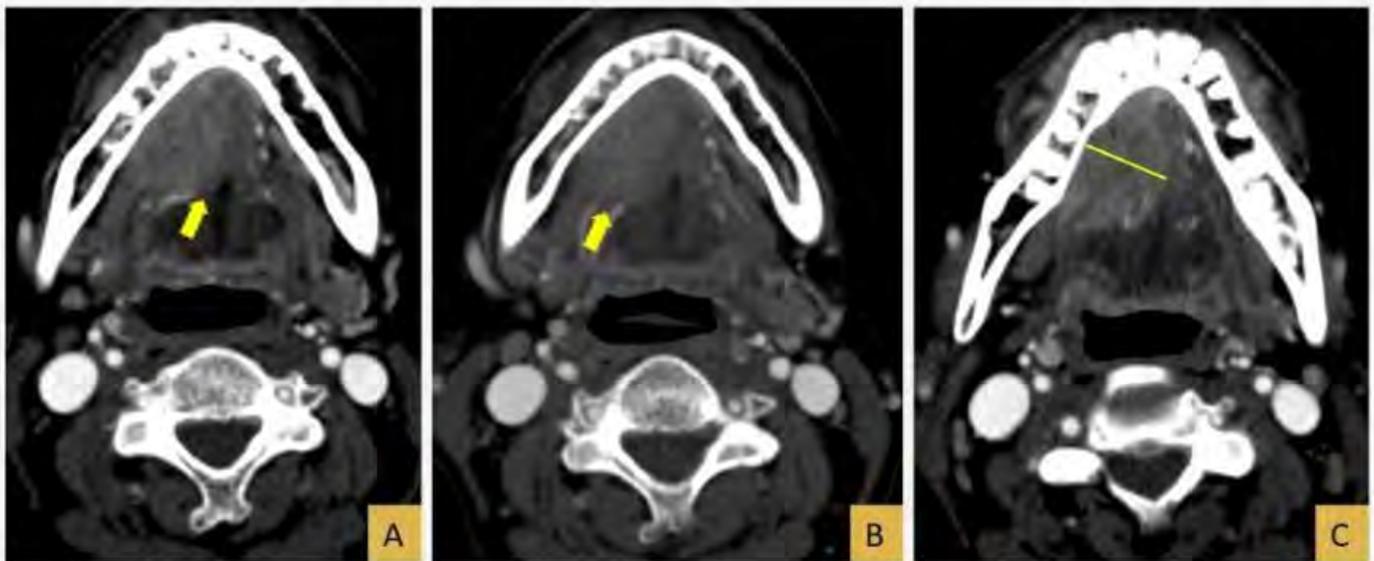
CT neck with contrast: Squamous cell carcinoma of the right floor of mouth. A) Arrow points to mass-like enhancement involving the right genioglossus muscle. B) Arrow points to mass-like enhancement involving the right hyoglossus muscle. C) Depth of invasion is approximated by measuring perpendicularly from the mucosal surface to the deepest edge of tumor on axial images.
